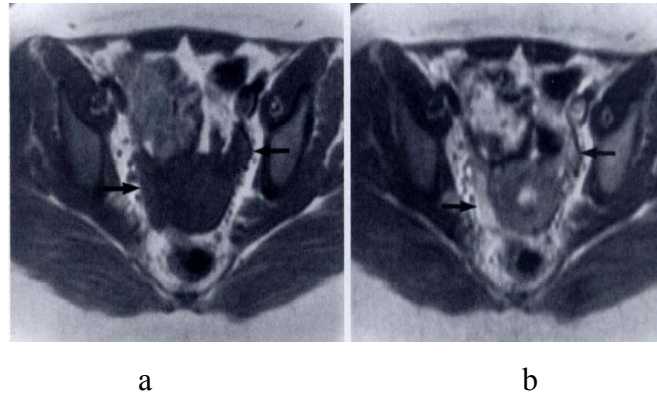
Normal ovaries in a patient of reproductive age. Axial T1-weighted (a) and T2-weighted (b) MR images demonstrate normal ovaries (arrows) (*Quoted from Olson et al., 1992*).
